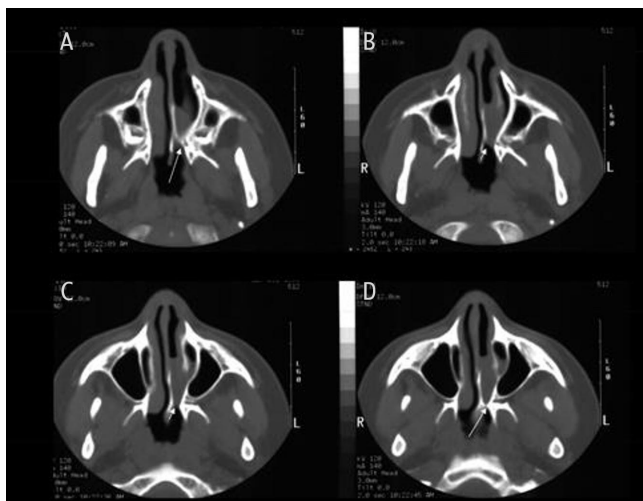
Axial maxillofacial CT demonstrating narrowing of the left posterior nasal airway due to bony (long arrows, panels A and D) and membranous soft tissue (short arrows, panels B and C) components, confirming left choanal atresia. Image from: Goldstein NA, Gitman L. Neonatal nasal deformities. *Neoreviews*. 2015;16(1):e36–e46³
